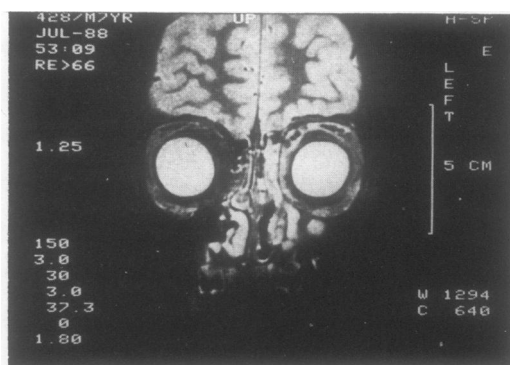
Coronal T2 weighted magnetic resonance image indicating diffuse involvement of left periorbital muscles.
